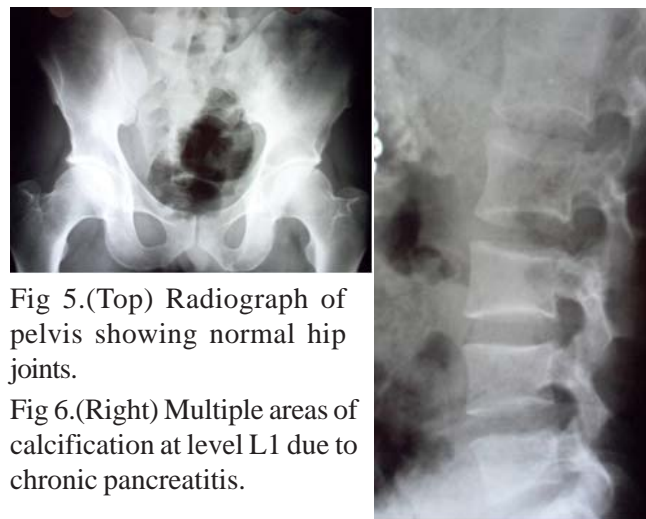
(Top) Radiograph of pelvis showing normal hip joints.
